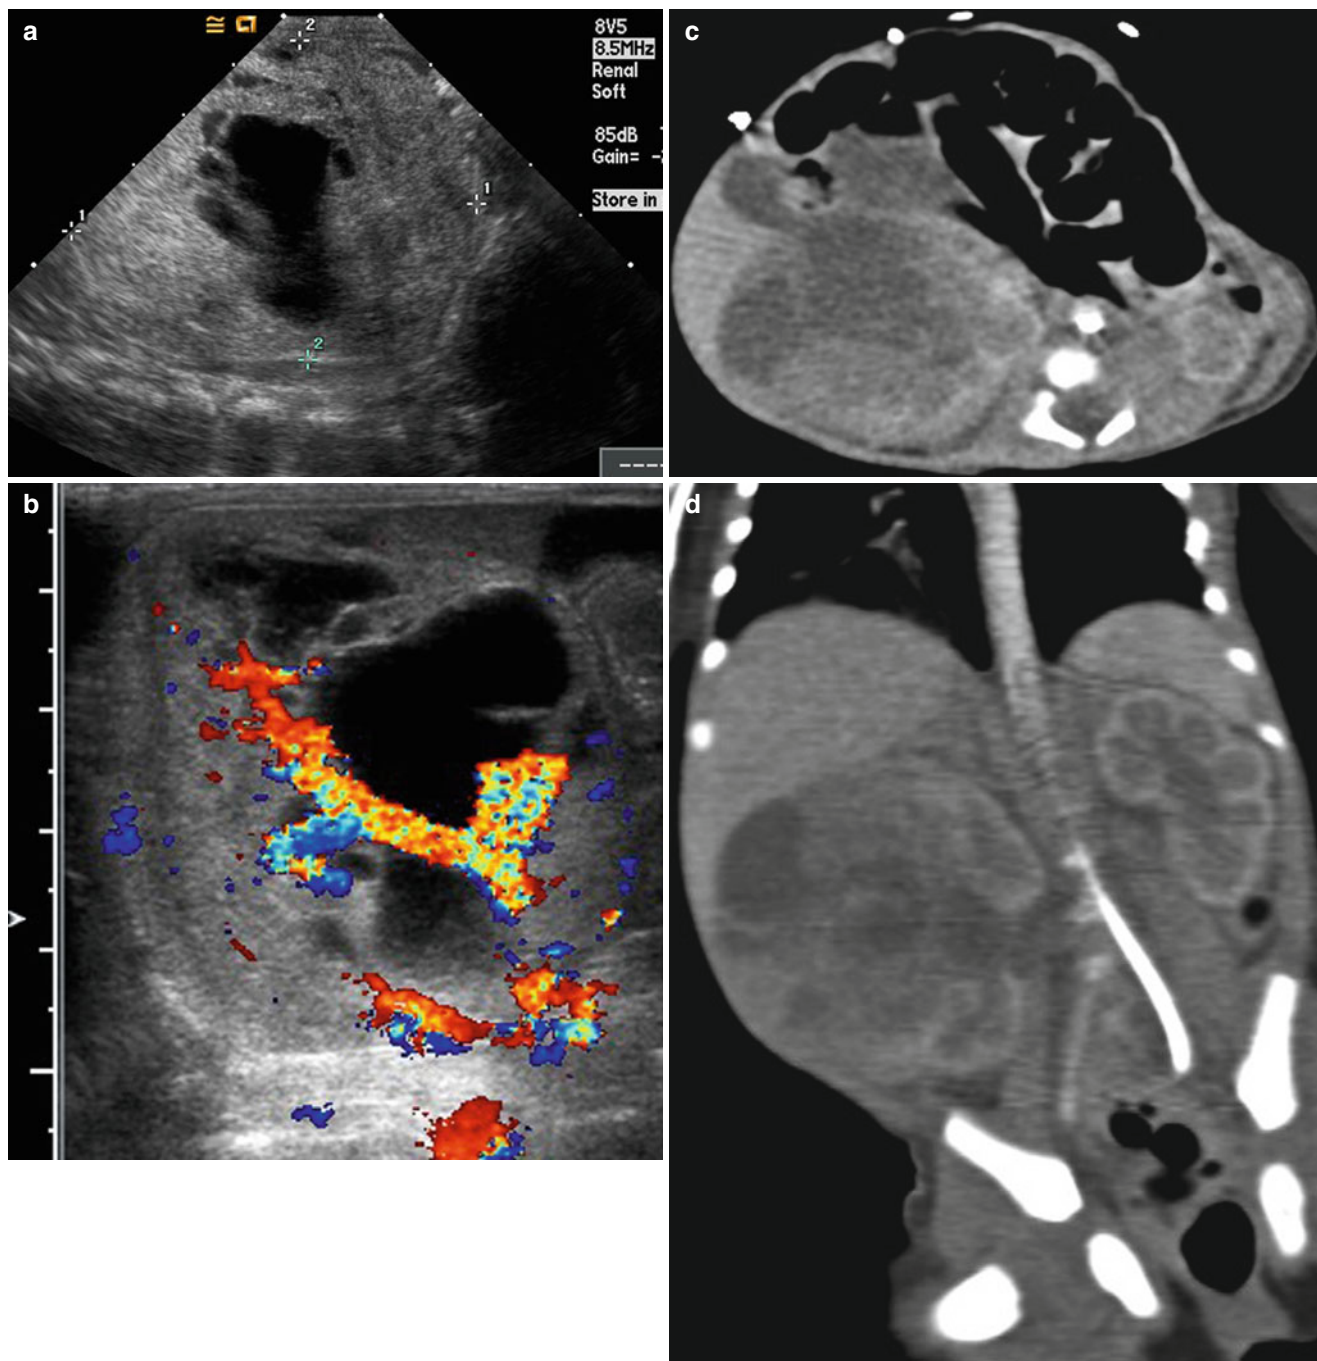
Congenital mesoblastic nephroma in a 2-day-old girl. (a) Longitudinal US of the right kidney shows a large mixed solid and cystic tumor arising from the right kidney. (b) Color Doppler US of the right kidney shows tumor vascularity within the mass. (c and d)
